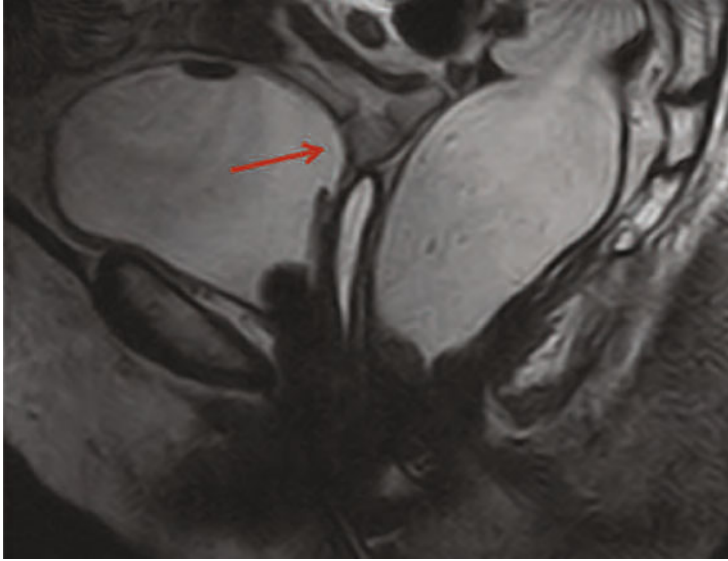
Magnetic resonance defecography performed on a 0.25 T magnet. T1-weighted gradient echo sequence acquired at rest in the sagittal plane. Ileal loops are visible in the rectovaginal space (*arrow*)
